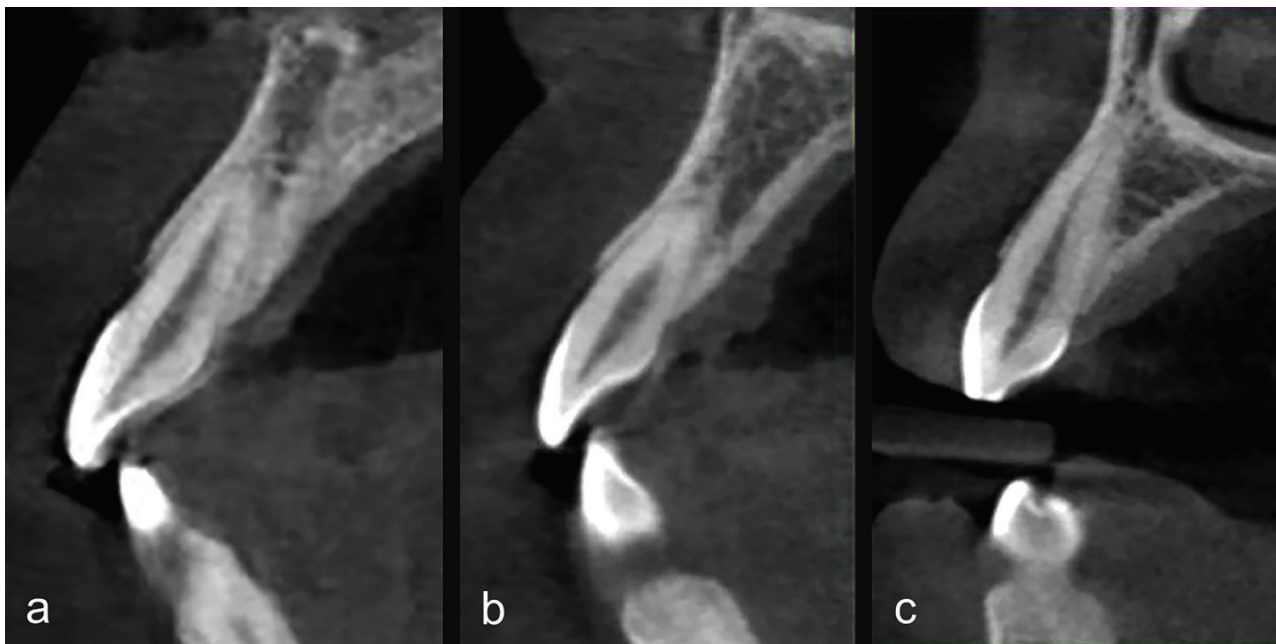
CBCT cross-section of a healthy maxillary central incisor demonstrating a thickness of buccal osseous plate along the roots length at different locations.
